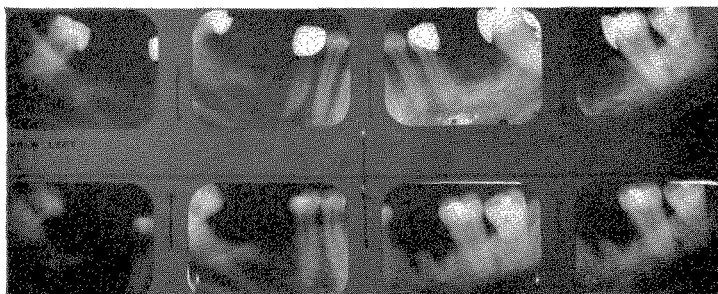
The lower roentgenograms were taken in 1934 before the insertion of the bridge shown in Fig. 425. The upper roentgenograms were taken in 1935 after the insertion of the right and left removable partial dentures.
